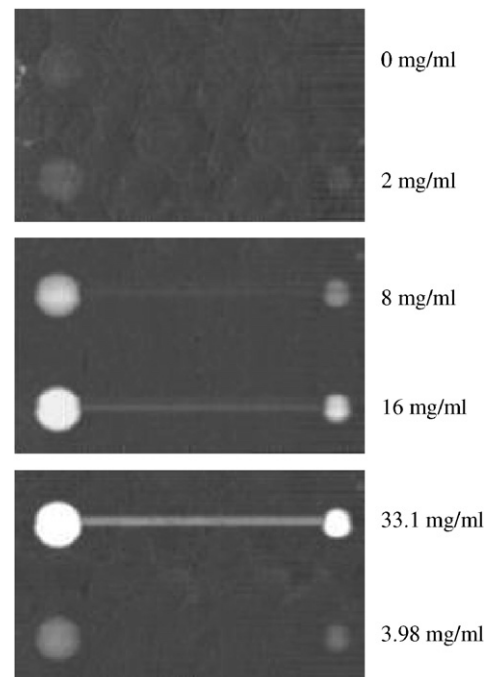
KESM technique with monochromatic X-rays. Final images obtained from initial images acquired at 32.5 and 33.9 keV for a total exposure of 1.84 mGy corresponding to a MGD of 1.73 mGy.
